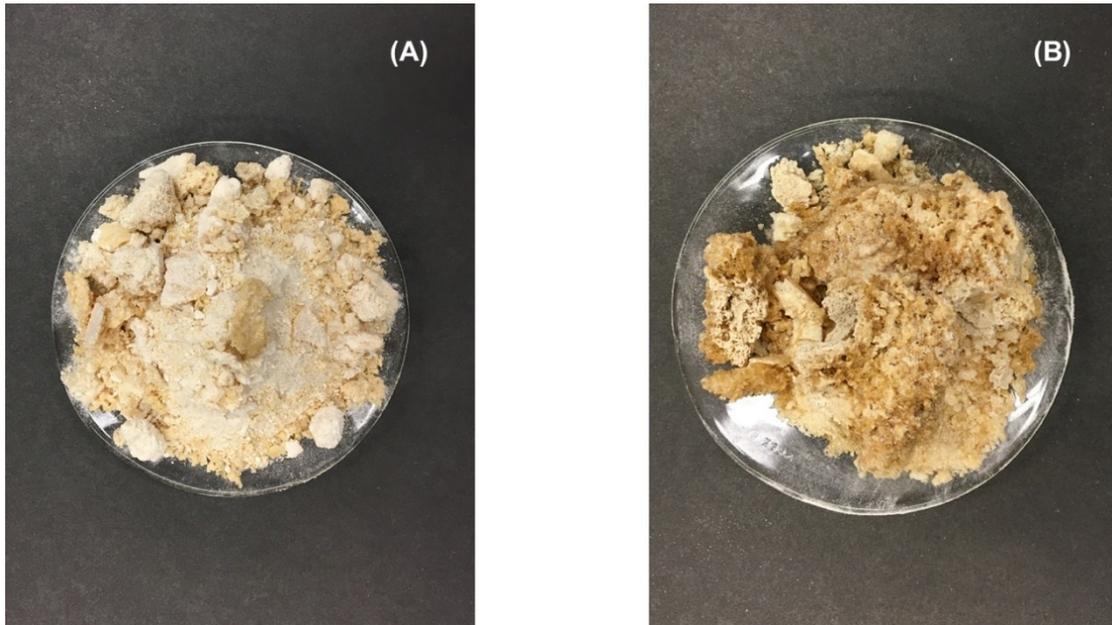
General Structure and Color of (A) untreated and (B) Ultrasound 10 min 300ml Whey Solution after Freeze Dry
